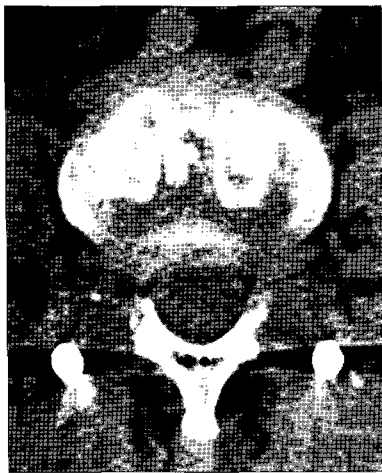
Postoperative computed tomography obtained after transforaminal lumbar interbody fusion.
